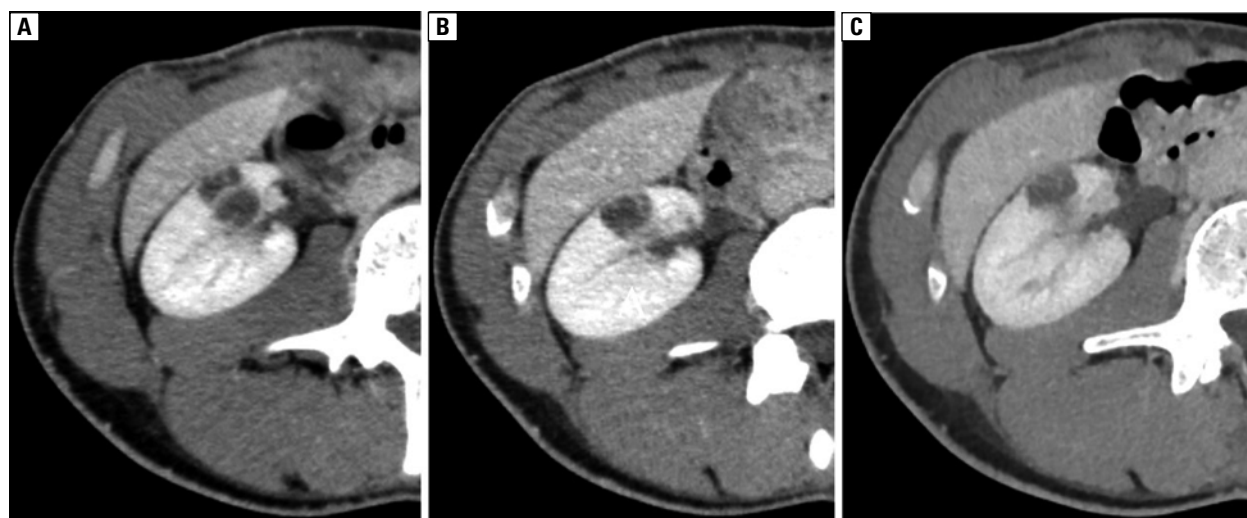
CT taken: A. 5 months; B. 8 months; C. and 17 months after initiation of crizotinib therapy
